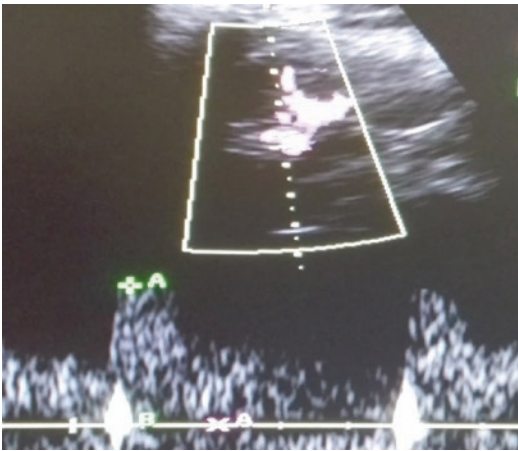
Doppler waveform in normal renal artery
